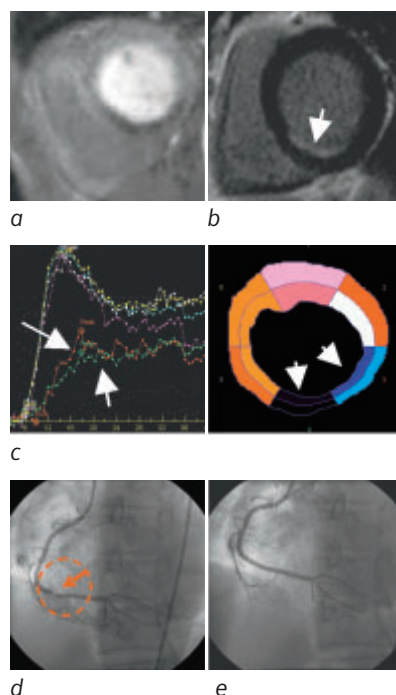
54 year old male patient with symptoms of chest discomfort unrelated to exertion. Patient is a non-smoker with no history of diabetes or hypertension. a) Stress perfusion image showing extent of perfusion deficit associated with RCA prior to stenting procedure, b) late enhancement image demonstrating subendocardial infarct, c) semi-quantitative perfusion curves displaying sector analysis of contrast transport through the myocardium. The arrows demonstrate the areas of risk highlighted by the perfusion software Dynamic Signal Analysis, d) X-ray angiogram before stenting, and e) angiogram after stenting.
